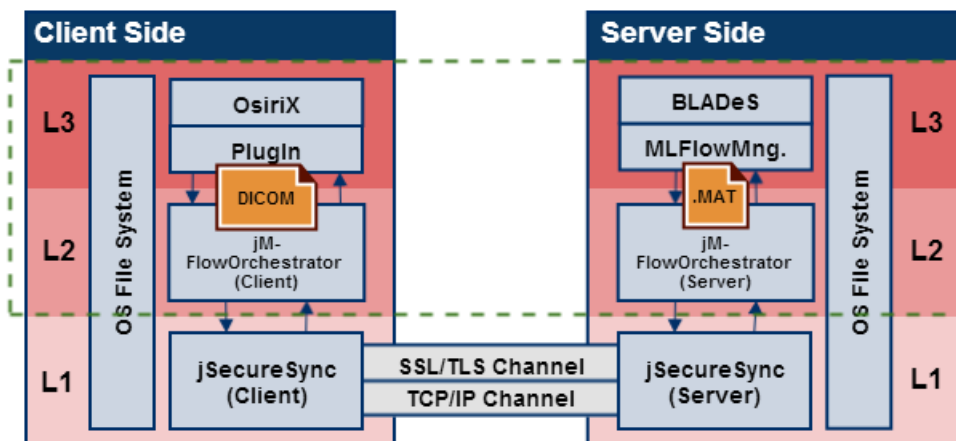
framework configuration in the specific context of DCE-MRI evaluation, by using OsiriX and the proposed CAD (Fig.1).
